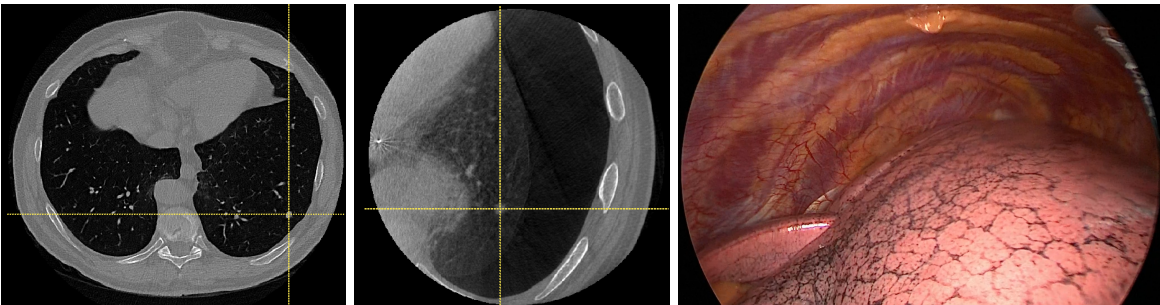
Left: Preoperative CT showing the lung nodule. Middle: Intraoperative CBCT showing the same nodule after lung deformation. Right: Endoscopic image where the nodule is not visible.
